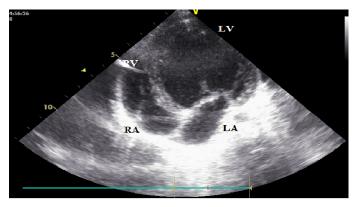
The 6-month follow-up echocardiographic examination. LV = left ventricle, RV = right ventricle, LA = left atrium, RA = right atrium
